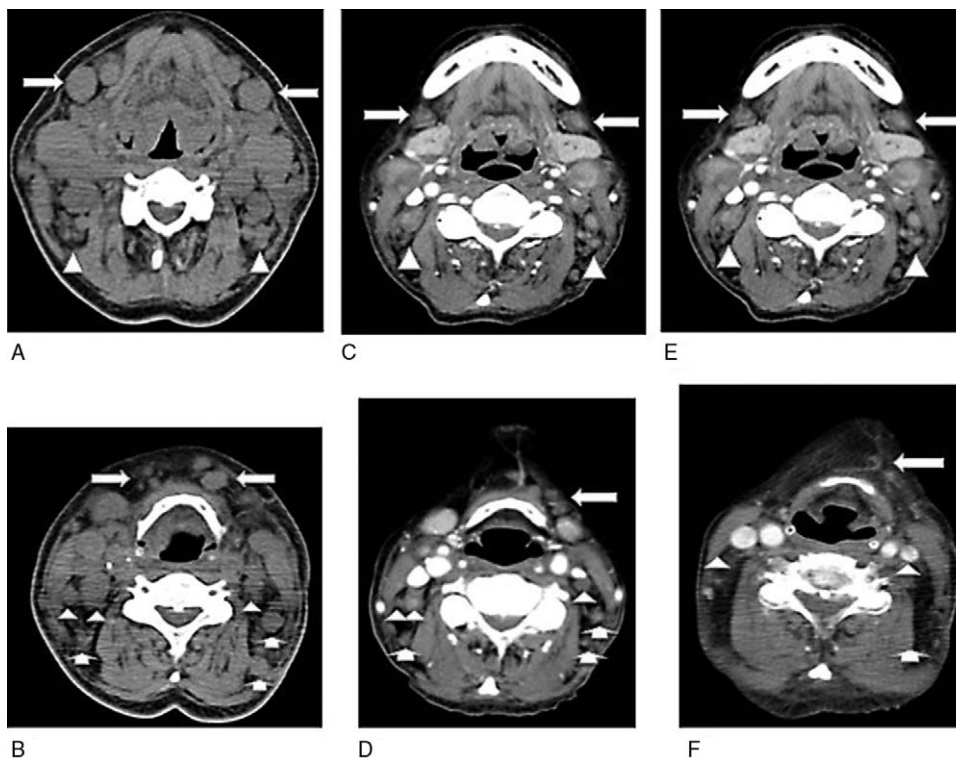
Neck computed tomography scan before (A, B) and after (C, D) 2 cycles of rituximab + gemcitabine + oxiplatin + L-asparaginase (R-pGEMOX) chemotherapy and after radiation therapy (E, F). (A, B) Lymph nodes enlarged in bilateral submandibular (IB) area (long arrow), carotid sheath (II) area (arrowhead), and accessory nerve lymphatic chain (VA) area (short arrow); (C, D) lymph nodes significantly decreased in size after the chemotherapy. (E, F) After radiation therapy, another decrease in the size of the lymph nodes was observed. R-pGEMOX=rituximab + gemcitabine + oxiplatin + L-asparaginase.
